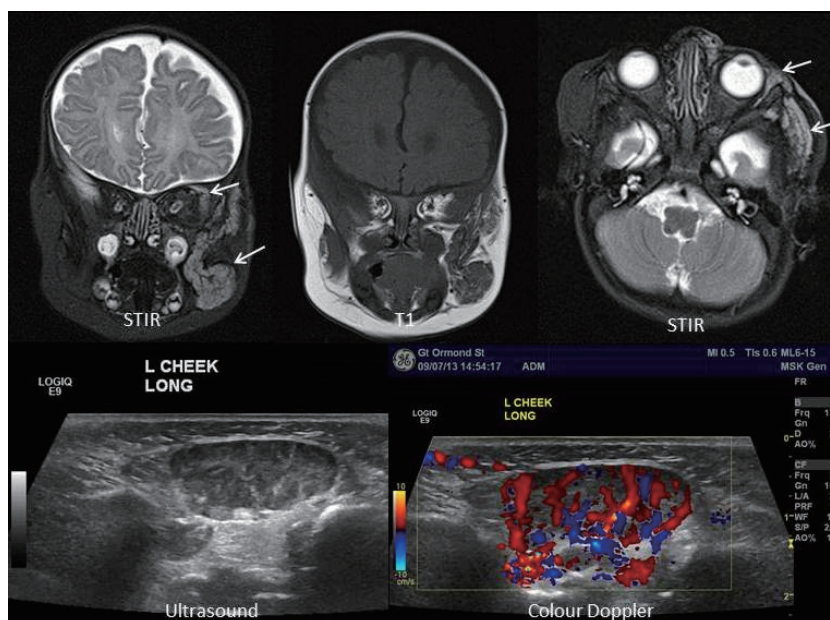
Infantile haemangioma on the face with orbital extension. Note the typical high vascularity demonstrated on colour Doppler ultrasound assessment.
